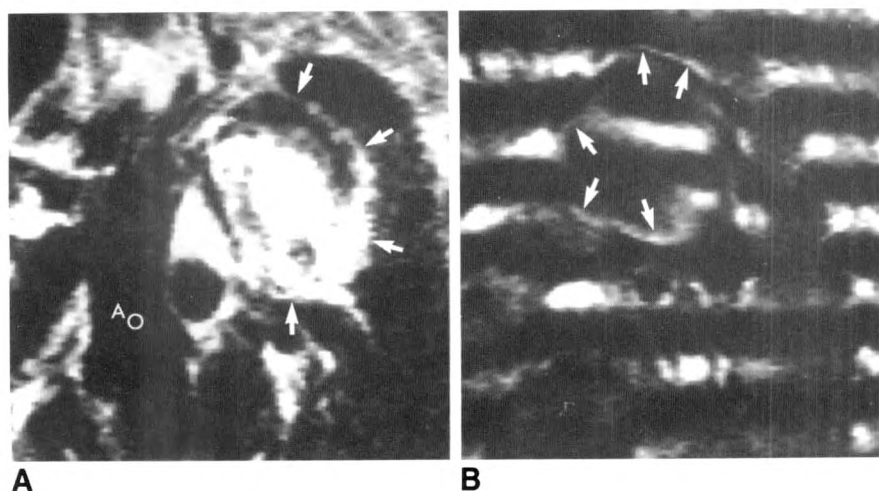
A, MR image of long axis of aortic arch in systole showing intense signal in a large saccular aneurysm (arrows). AO = ascending aorta. B, Phase-shift image showing deflection of phase stripes in aneurysm (arrows) with a chaotic pattern, indicating that signal arose in slowly flowing blood.
